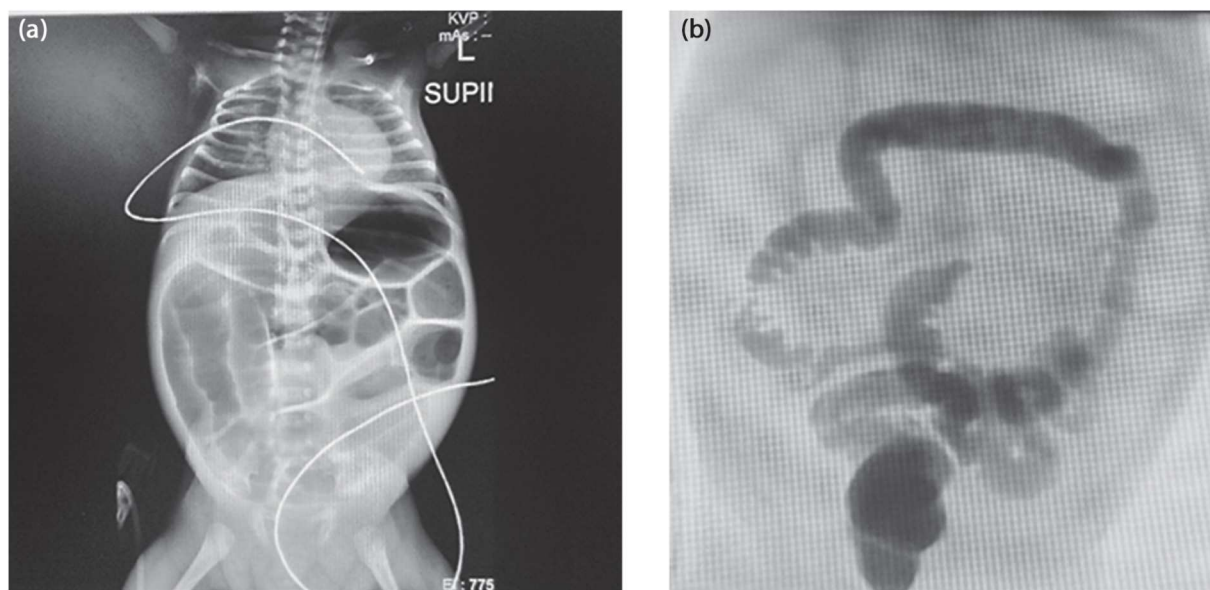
(a) Abdominal radiograph demonstrating multiple dilated bowel loops; (b) contrast study revealing the presence of an ileal stricture.
